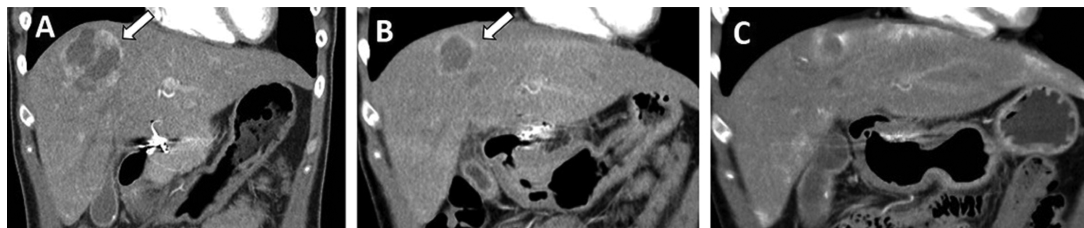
Follow-up computed tomography (CT) scans 1.1 months (A) and 7.3 months (B) after yttrium-90 selective internal radiation therapy revealed reduced size of liver metastases. A CT scan showed complete remission of the hepatic metastases 1.1 months after radiofrequency ablation (C).
